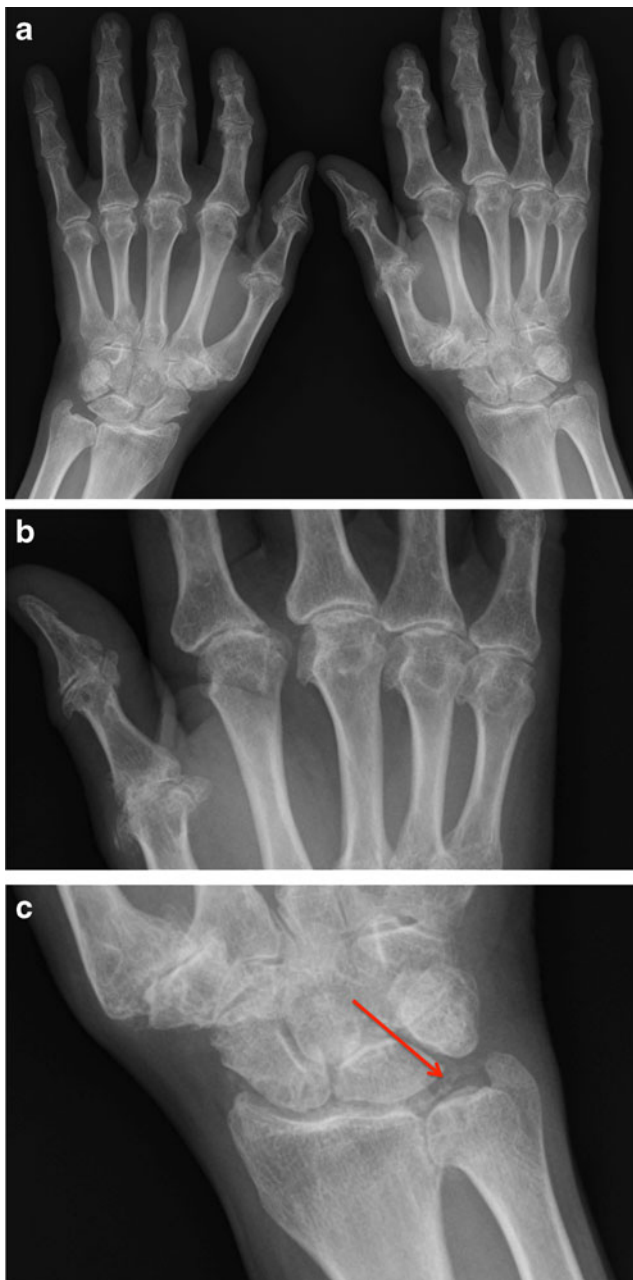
Hemochromatosis arthropathy. Conventional X-ray of the hands showing severe degenerative arthritis in a 76-year-old male patient with HFE-related hemochromatosis: involvement of the MCP joints with joint space narrowing, subchondral sclerosis, hook-like osteophytes (a, b). Severe OA of the interphalangeal joints and thumb OA is also detectable. Chondrocalcinosis is present in the wrist (*arrow*, c)
